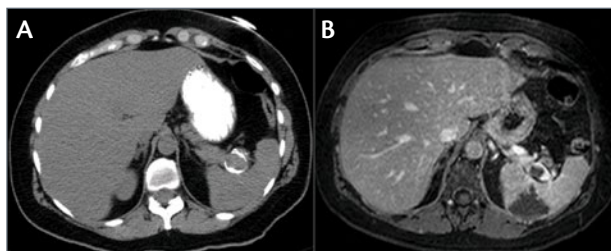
Noncontrast CT scan showing a 2.5-cm calcified distal splenic artery aneurysm with no evidence of hemoperitoneum to suggest rupture (A). A magnetic resonance imaging scan with contrast shows a distal splenic artery aneurysm with intraluminal thrombus and associated wedge-shaped splenic infarction (B).
